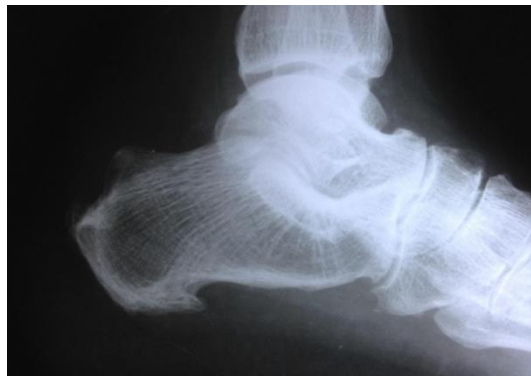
lateral radiograph of foot showing a calcaneal spur
